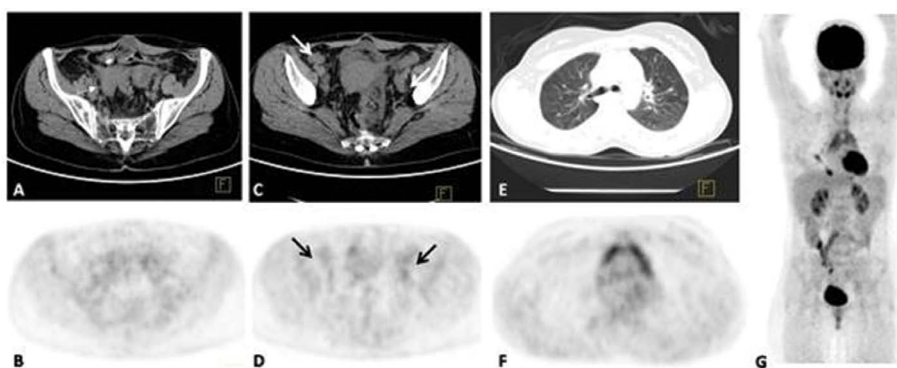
Follow-up [¹⁸F]FDG PET-CT scan showing prominent metabolic response to tuberculostatic treatment
